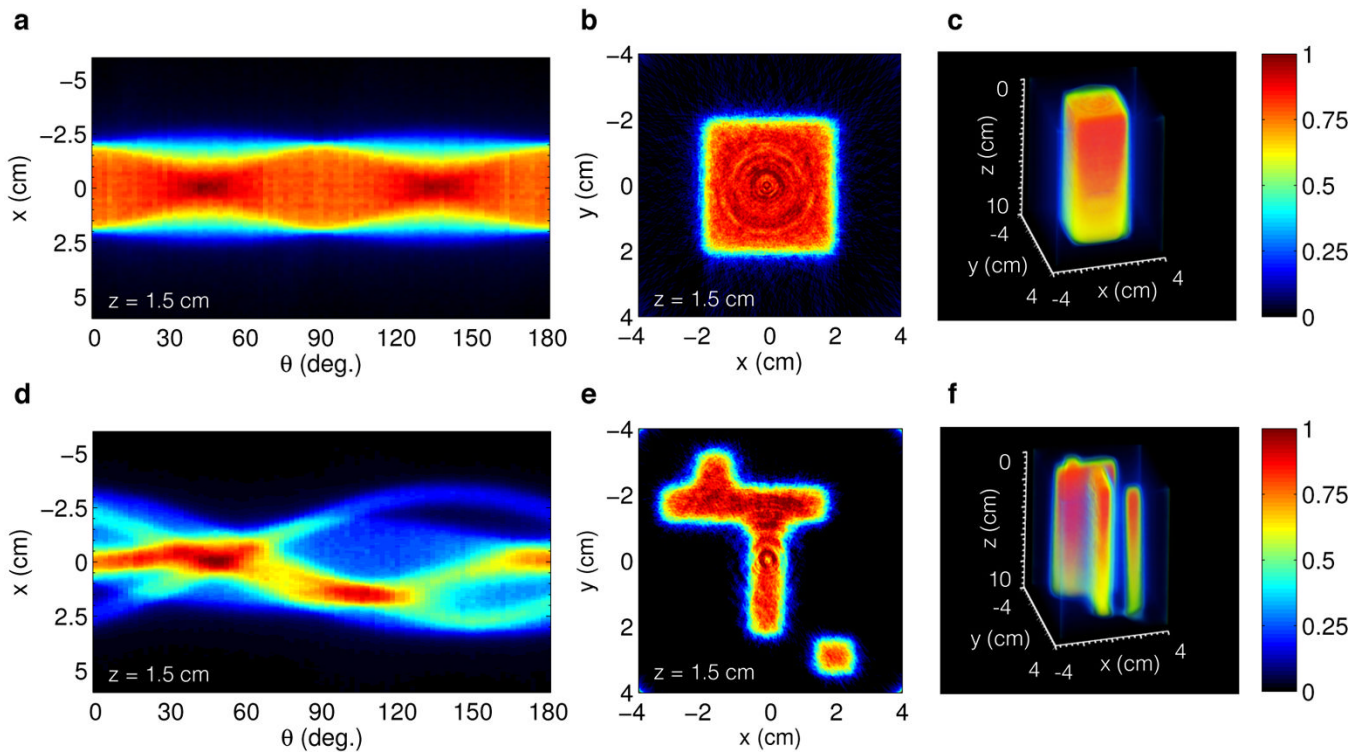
In (a,b) and (d,e) the sinogram and reconstructed cross section for Field A and B respectively. In (c) and (f) the full 3D reconstruction of Field A and B to a depth of $z = 10$ cm. The intensity decreases with depth due to exponential attenuation of the primary x-ray photon beam.
